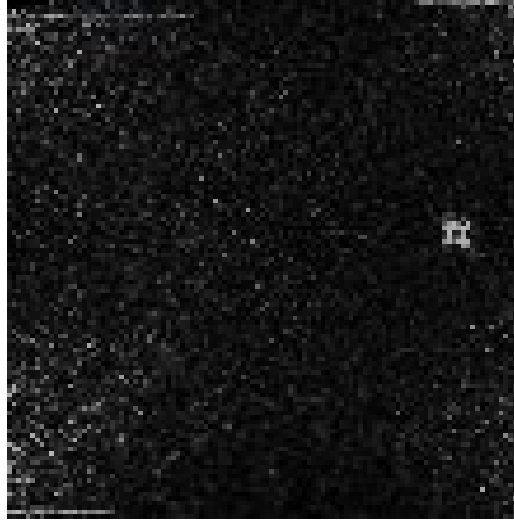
MR image the π -FBG-2 based acousto-optic sensor using a fast bSSFP sequence and the device receiver channel only.
